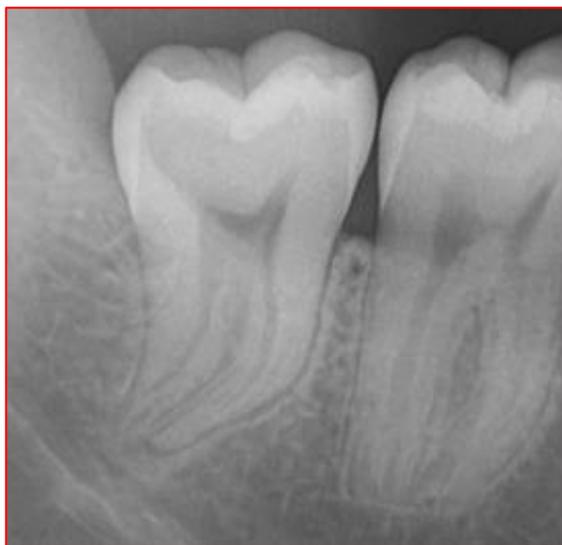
Periapical image showing a mandibular third molar with dilacerated root.
